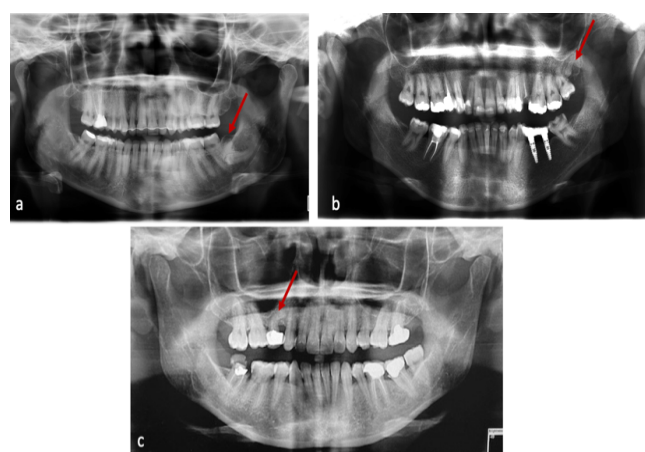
a-) Panoramic radiograph showing impacted tooth #38 with associated pericoronal pathological lesion. b-) Panoramic radiograph showing impacted disto-molar with microdontia distal to tooth #28. c-) Panoramic radiograph showing sharp dilaceration in tooth #14.
